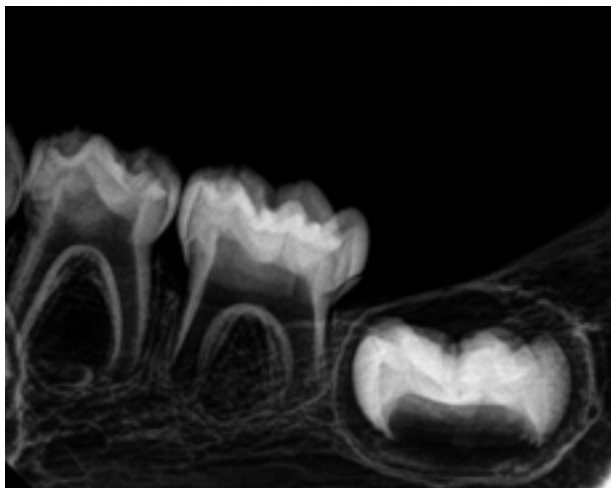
Periapical radiograph depicting the left mandibular deciduous molars and an unerupted permanent first molar.
